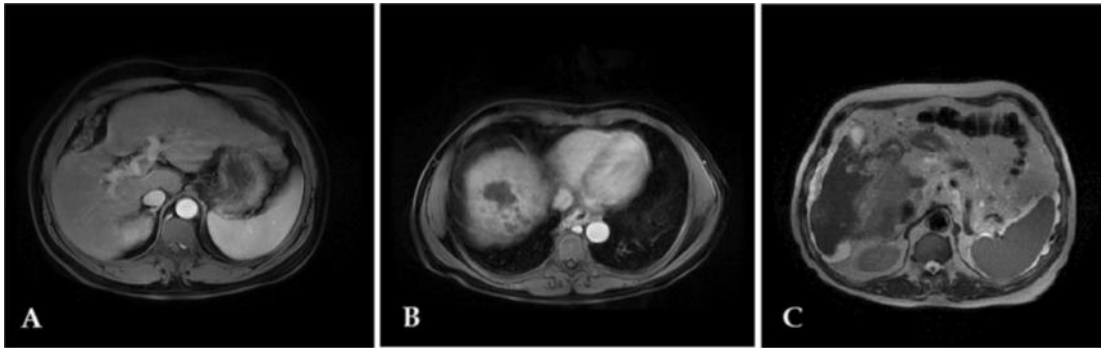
(A) MRI arterial phase bland thrombus with no enhancement. (B) MRI DWI restricted PV thrombus and HCC at RT lobe. (C) MRI T2WI HCC and malignant PV thrombus lost vascular signal void [10].
